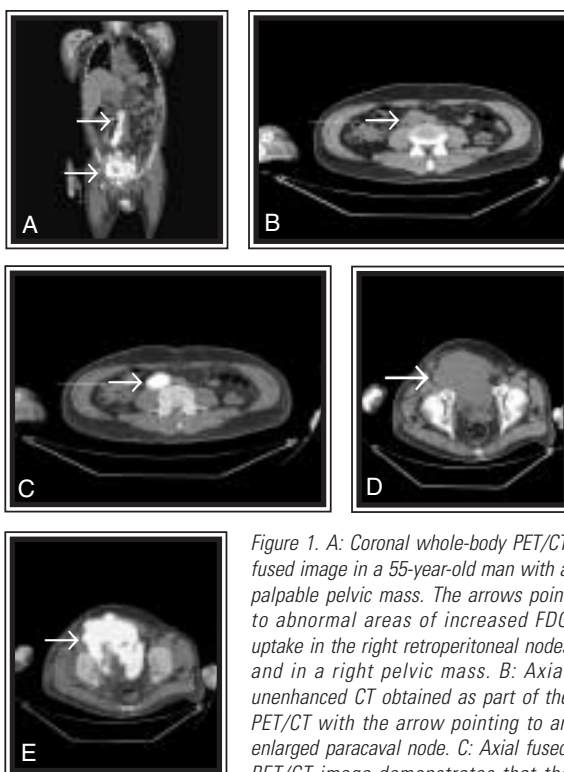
A: Coronal whole-body PET/CT fused image in a 55-year-old man with a palpable pelvic mass. The arrows point to abnormal areas of increased FDG uptake in the right retroperitoneal nodes and in a right pelvic mass. B: Axial unenhanced CT obtained as part of the PET/CT with the arrow pointing to an enlarged paracaval node. C: Axial fused PET/CT image demonstrates that the enlarged paracaval node has significant FDG uptake, consistent with metastases. D: Axial unenhanced CT obtained as part of the PET/CT with the arrow pointing to an anterior right pelvic mass, which involves the anterior right pelvic musculature. E: Axial fused PET/CT image demonstrates that the right pelvic mass has markedly increased FDG uptake consistent with a metastatic lesion.
